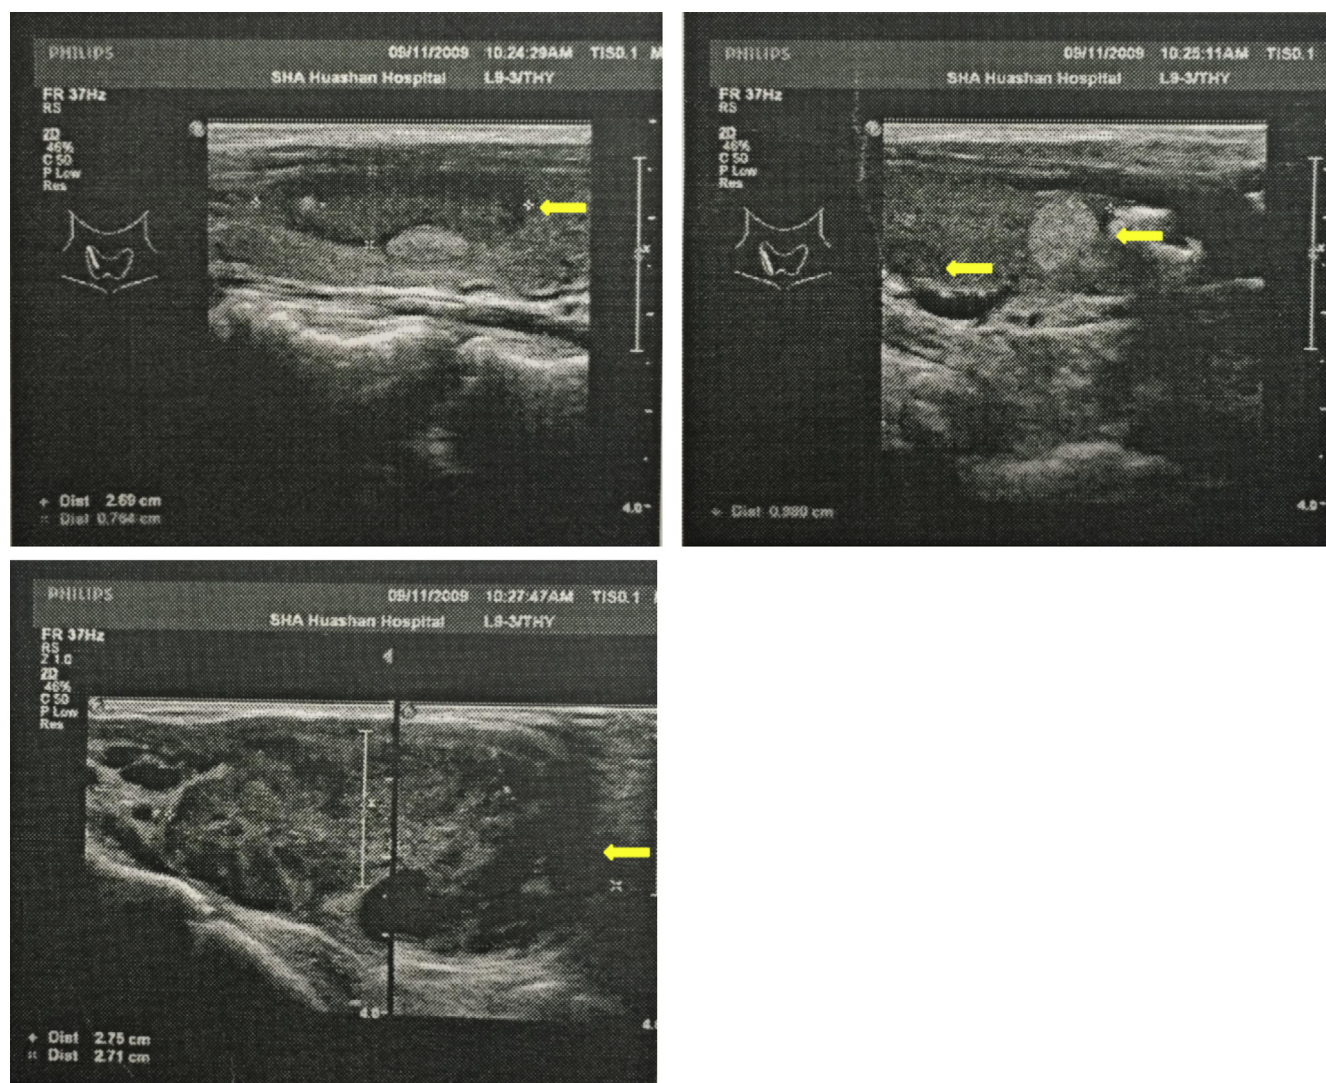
Ultrasound showed that the thyroid gland was enlarged with many nodules of varying sizes and presenting uneven echo.
